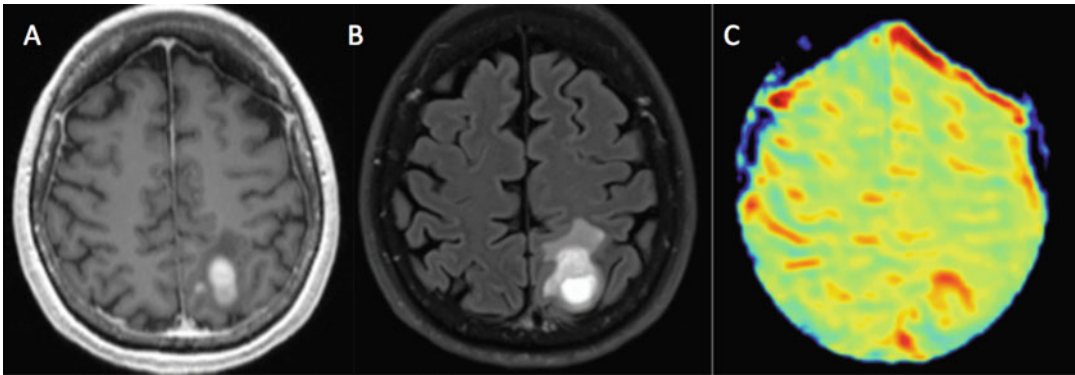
Postgadolinium T1w (a), FLAIR (b) and APT-CEST (c) imaging in a patient with WHO III astrocytoma. Increased APT signal appears confined to the tumor periphery, suspected to reflect greater focal
